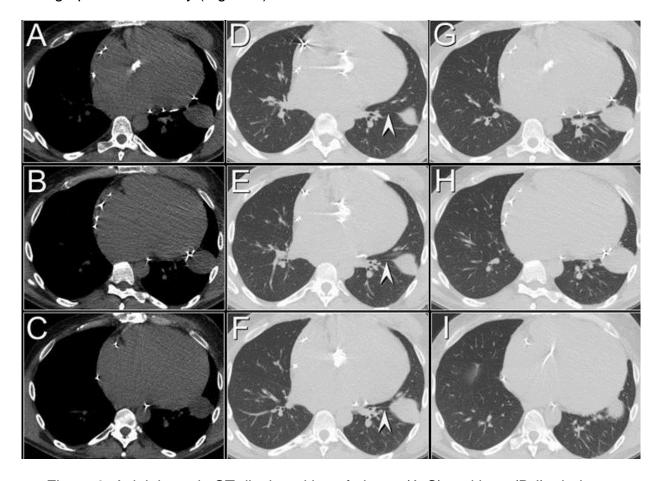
Axial thoracic CT displayed in soft tissue (A-C) and lung (D-I) windows.
